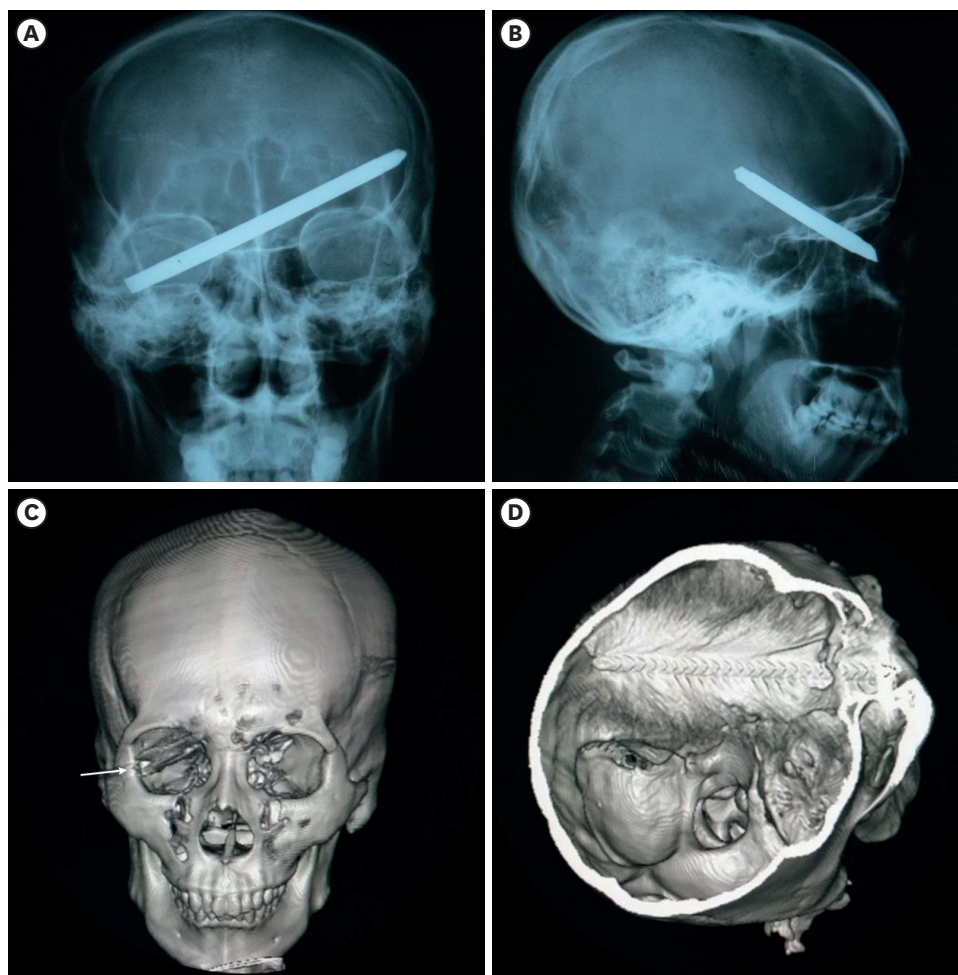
The supportive examination shows an object traverse obliquely inside the intracranial cavity. (A, B) The skull X-ray in (A) anteroposterior and (B) lateral view. (C, D) The 3D reconstruction shows (C) an object inside the orbital cavity (white arrow) and (D) traversed intracranially.
